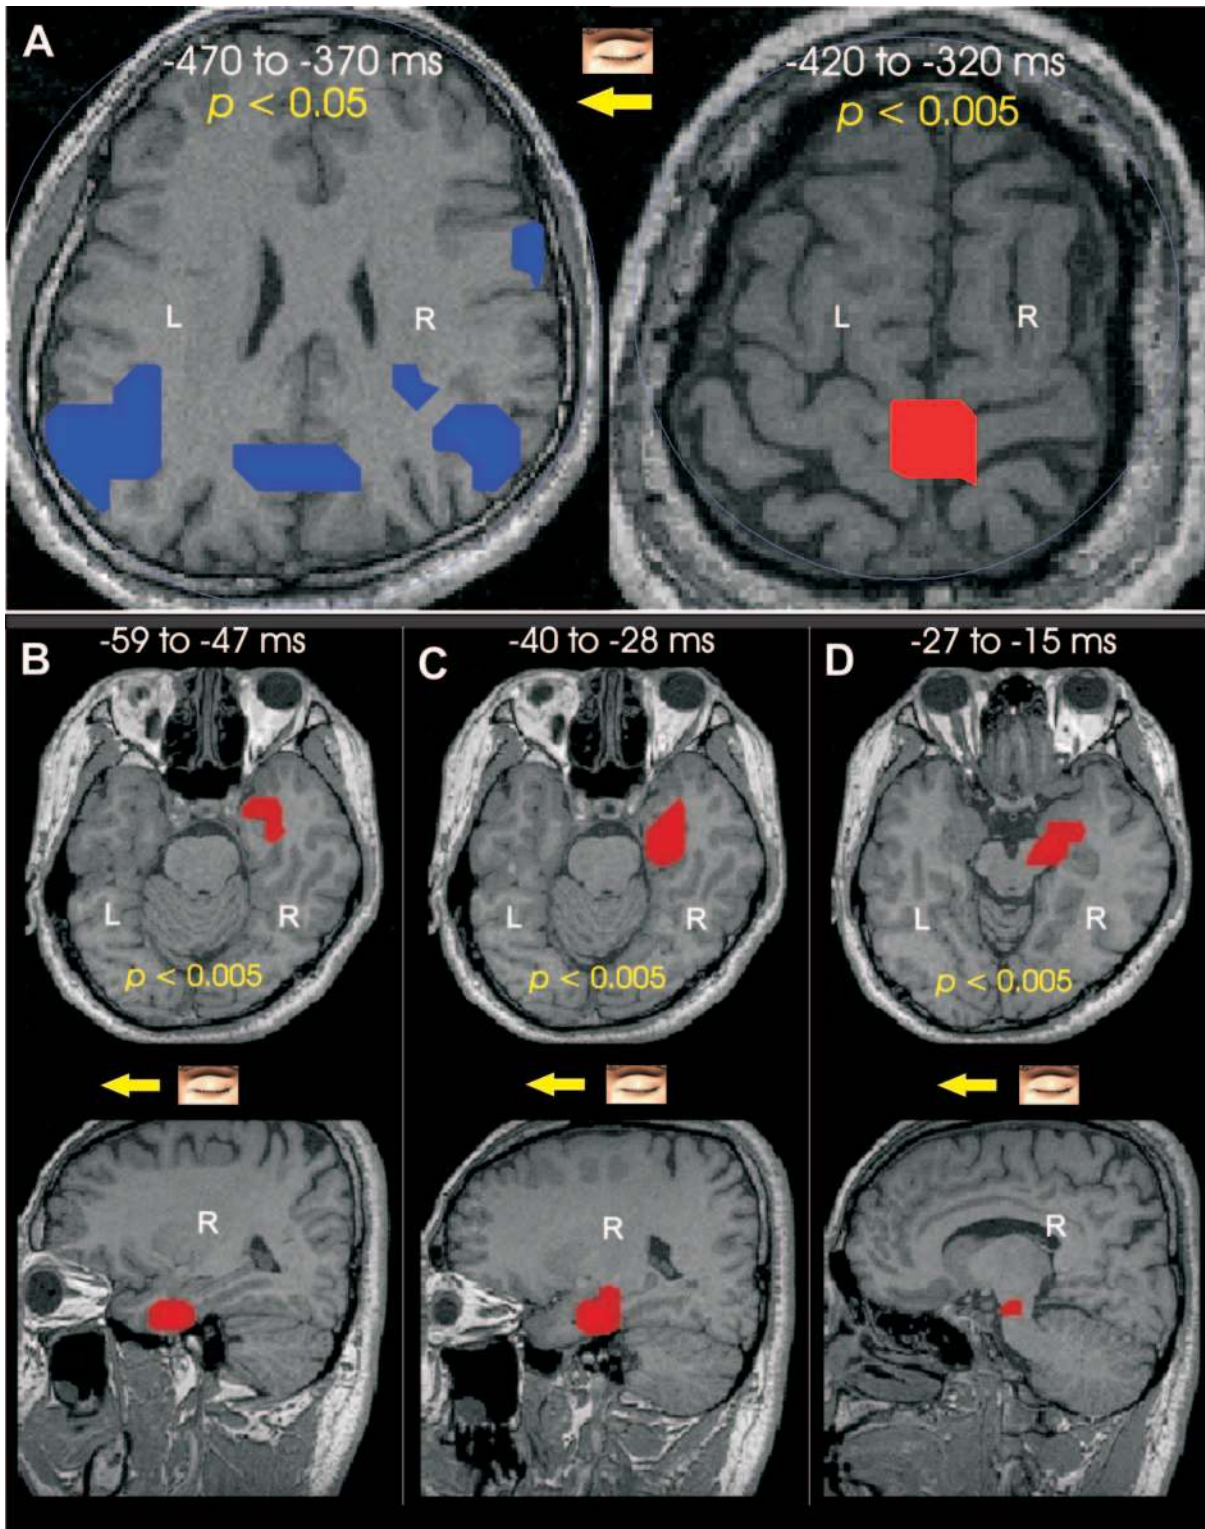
Grand SPMs for leftward eye movements. The loci of common changes are identified after the data from each subject are transformed into the Talairach space (coordinates of areas in Table 1). The common loci for the three subjects are displayed after back-transforming the results and projecting them onto the MRI of one subject (red — increase, blue — decrease; the time interval and the threshold P -value are printed inside each figurine). (A) Examples of the persistent changes from comparison with long (100 ms) windows, left picture REMS contrast with ECW, right picture REMS contrast with OCS and SPS. (B–D) Axial and sagittal MRI slices for three successive SPMs leading to saccade onset (the contrast is REMS to the left versus ECW using 12 ms windows). The SPMs show a sequence of relative increase of right hemisphere activity in REMS beginning in the orbitofrontal cortex and amygdala (B), followed by activity in the PHG (C) and finally PN (D).
